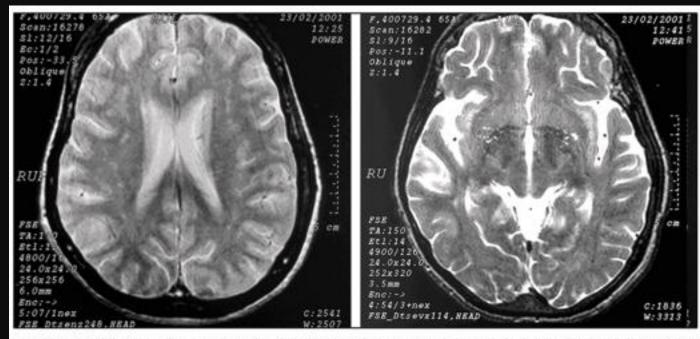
Sixty five year-old patient with a diagnosis of vascular parkinsonism. The magnetic resonance image revealed perivascular space enlargement in the basal nuclei and cerebral peduncles as well as ischemic lesions in the white periventricular and subcortical matter.
